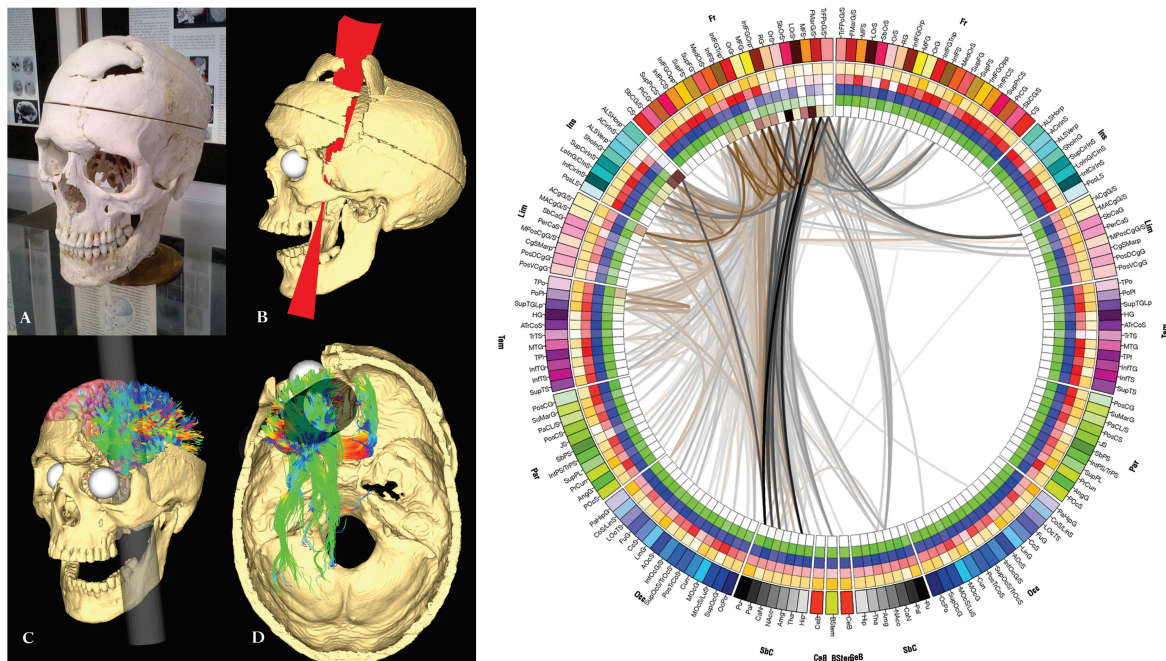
Reconstruction of Phineas Gage's damage from the work made by Van Horn and colleagues [122]. The skull on display at the Warren Anatomical Museum at Harvard Medical School, computed tomography image volumes, rendering and view of the interior of the skull and the connectogram are shown.
